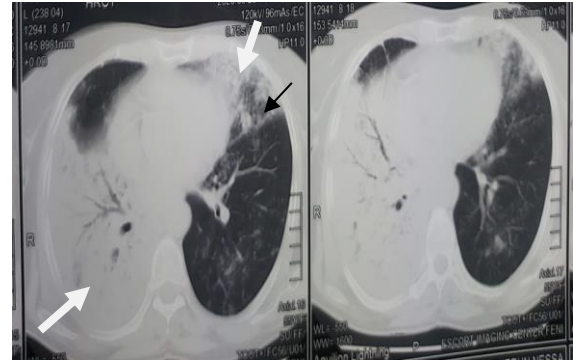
(A, B). Coronal view of CT Chest showing large areas of consolidation having air bronchogram at almost all segments of right lower lobe. Multifocal areas of consolidations surrounded by ground glass densities are noted. Small cavitary lesions also noted in the apical region of both lungs. White arrows: lesions of COVID-19. Black arrows: probable lesions of TB.
